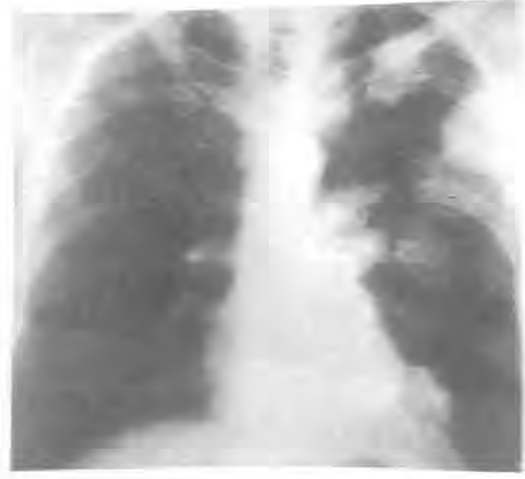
Frontal chest roentgenogram showing multiple intact echinococcal cysts in the left lung
